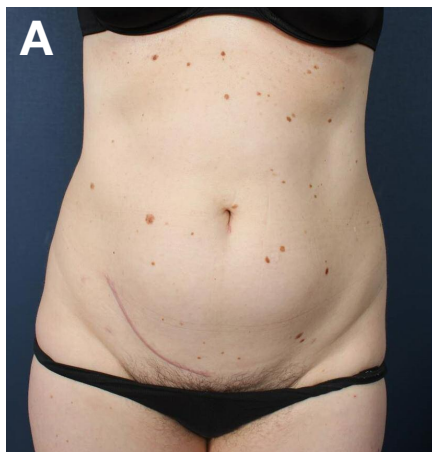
(A) frontal view before treatment, (B) frontal view 3 months after treatment, (C) lateral view before treatment, (D) lateral view 3 months after treatment, (E) Duplex sonography before treatment, (F) Duplex sonography 3 months after treatment with a layer thickness reduction of approx. 1.5 cm.
